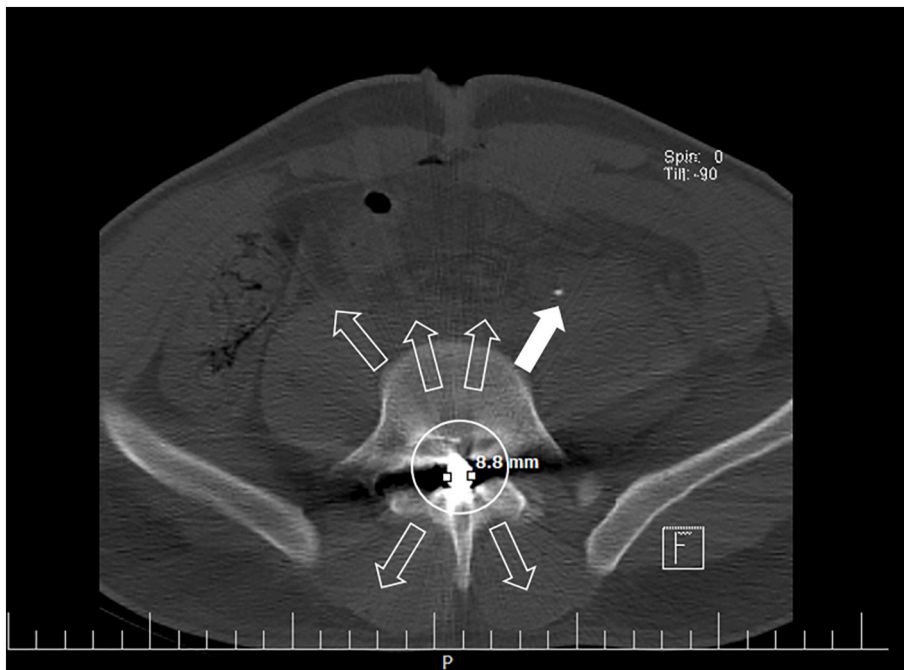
Axial CT scan sequence of the patient after first surgery at the L5 vertebral level showing the bullet placed into the spinal canal in a circle measuring about 8.8 mm in diameter. There are no multiple osseous fragments present at this level. The hollow arrows represent the metal artefact. A section of double J tube into the left ureter is also seen (solid arrow).
